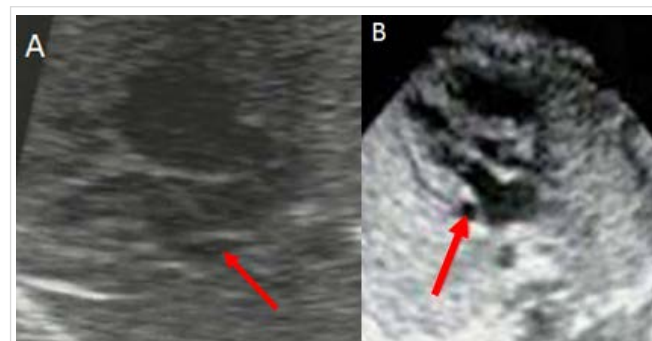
Four-chamber echocardiographic view (A) left ventricular long-axis view (B). The arrow highlights the dilated coronary sinus in both cases.
